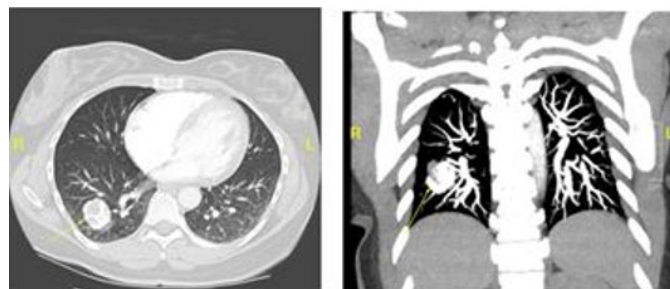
CTA chest in axial and coronal views demonstrating a mass in the right lower lobe measuring up to 2.9 cm with multiple areas of enhancement suspicious for vessels/internal pseudoaneurysms.
